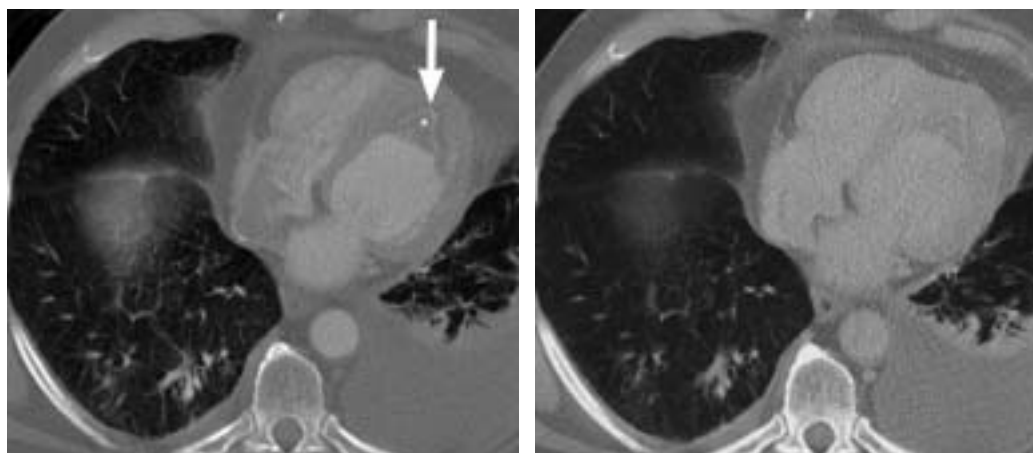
Cardiac computed tomographic images clearly identify a noncalcified mass filling much of the left ventricular apex. Left, Most of the mass (asterisk) shows no contrast enhancement, although a rim of hyperenhancement (arrow) is seen on delayed image. Right, The mass abuts and is adherent to the myocardium but does not appear to invade it. No left ventricular aneurysm or diverticulum is present.
